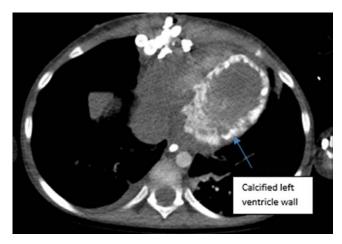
Axial computerized tomography (CT) scan showing markedly abnormal, diffusely calcified left ventricular wall.
